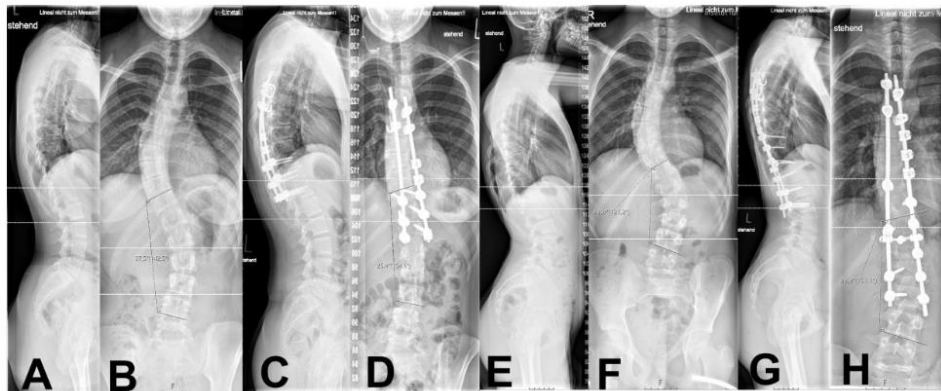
Two example cases for the impact of the distance between the LIV and the sagittal IP on the correction of the minor curve. In both cases the minor curve could be identified as nonstructural in the bending radiographs A-D showing pre- and postoperative x-ray of a patient where the IP and the LIV are on the same level. In this case a correction of the minor curve from 37° to 25° was achieved. E-F showing pre- and postoperative x-ray of a patient where a distance of 3 vertebrae was between the IP and the LIV. In this case a correction of the minor curve from 48° to 28° was achieved.
